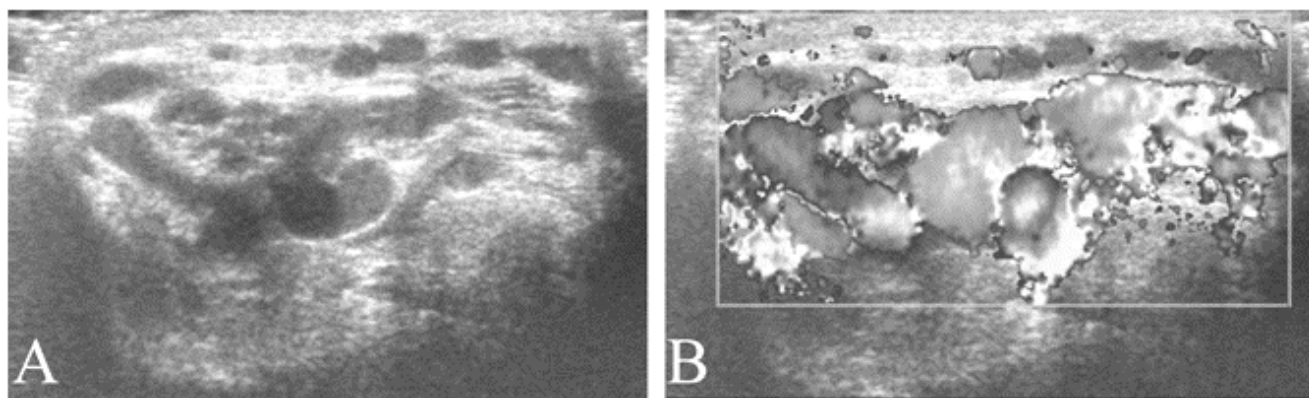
Varicocele in a 16 year old with a painless mass in the left scrotum. A. Gray-scale ultrasound of the mass in the scrotum shows the typical “bag of worms” appearance of a varicocele. B. Color Doppler exam demonstrates extensive flow through the lesion.
